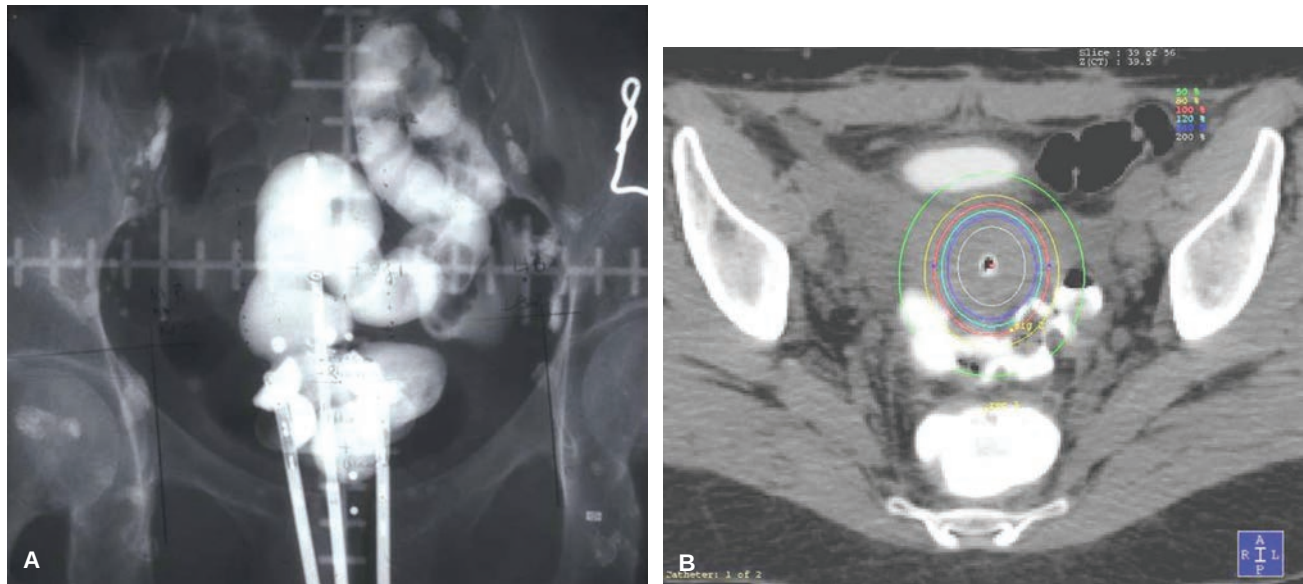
Radiograph of the pelvis with a tandem and ovoid applicator in place demonstrates the circuitous course of the sigmoid A. The axial CT scan B demonstrates a more accurate relationship of the sigmoid to the uterine tandem and the need to limit dose to this loop of sigmoid positioned very close to the high-dose region of the implant.
